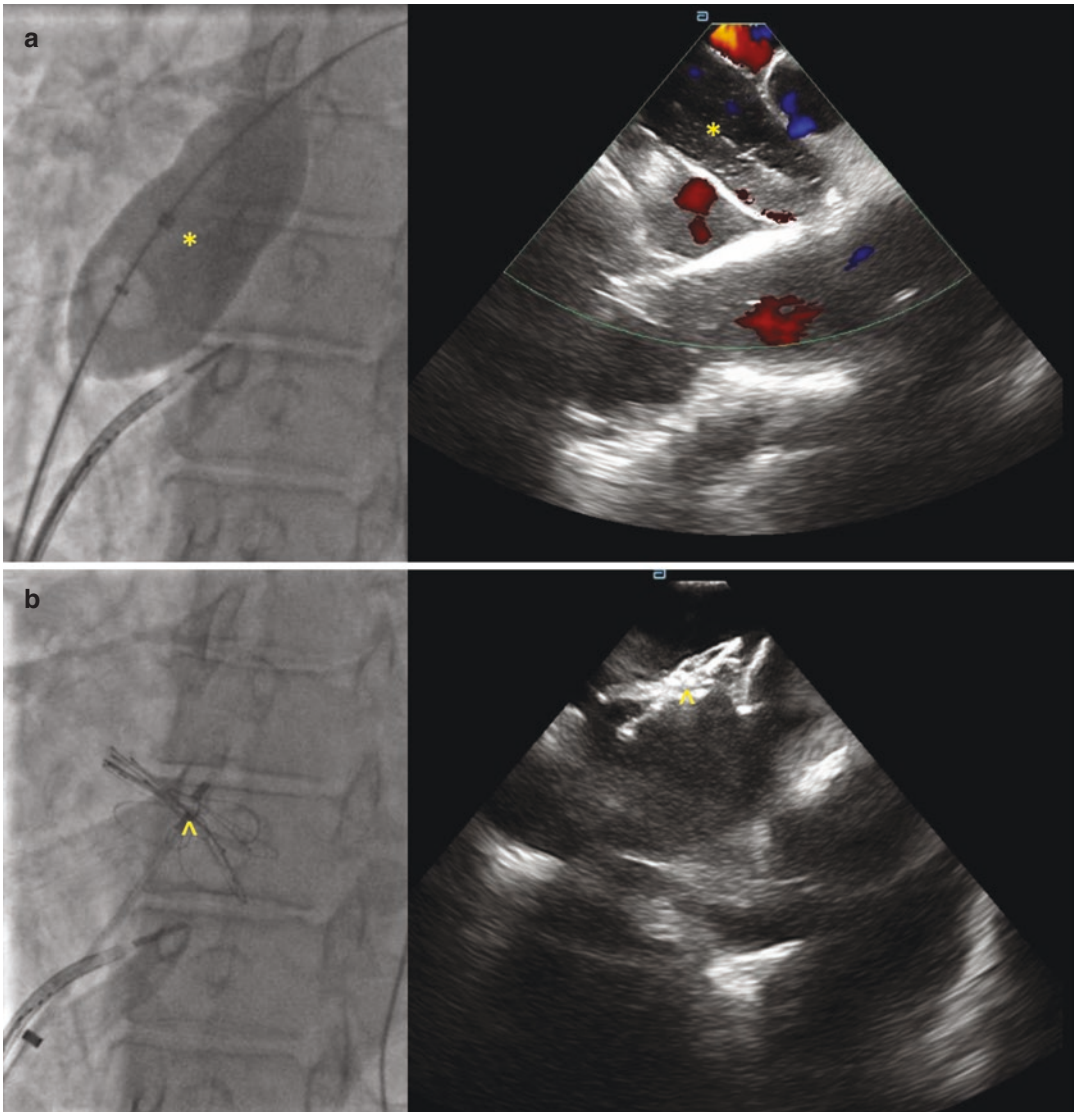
Closure of an Atrial Septal Defect (ASD) with a Gore Cardioform ASD Occluder. (a) Balloon sizing the atrial septal defect (ASD). The left pane is a fluoroscopic image of the sizing balloon across the ASD. Note the small waist. The right pane is an intracardiac echo (ICE) image of the sizing balloon across the defect, with no evidence of Doppler color flow around the balloon.
